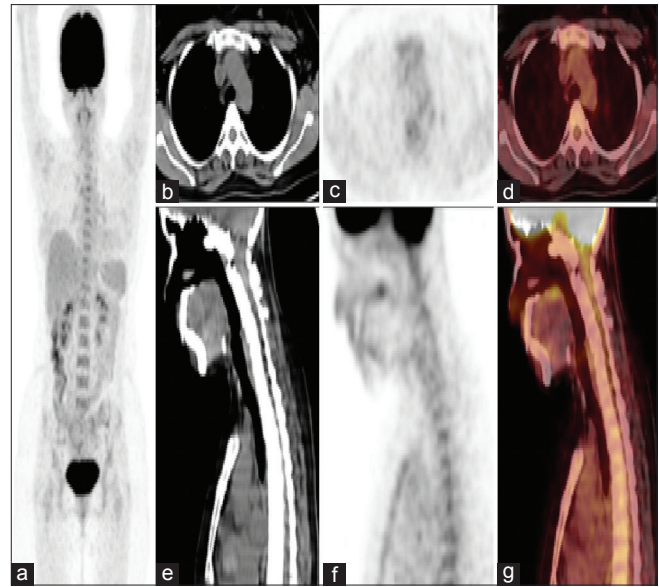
Case 3 (posttreatment): Maximum intensity projection image (a), axial (b-d) and sagittal (e-g) sections of computed tomography, positron emission tomography and fused positron emission tomography-computed tomography images showing no evidence of abnormal fluorodeoxyglucose uptake in aortic wall with maximum standardized uptake value: 2.6 and arch of aorta maximum standardized uptake value: 2.6 (liver maximum standardized uptake value: 2.9)
